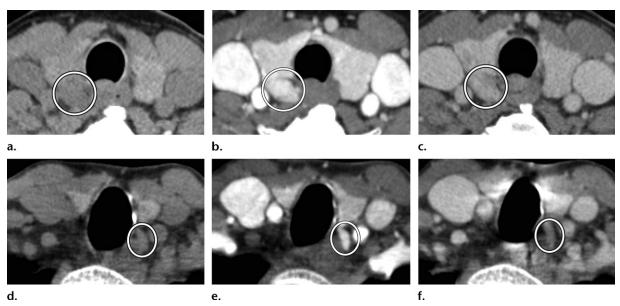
Classic parathyroid adenoma appearance at 4D CT in two patients. Images a-c were obtained in one patient, and images d-f were obtained in a second patient. Axial 4D CT images show that the parathyroid adenomas (circle) are hypoattenuating relative to the thyroid on non-contrast-enhanced images (a, d), are hyperattenuating on the arterial phase images (b, e), and are hypoattenuating (washout) on the venous phase images (c, f). This enhancement pattern is also referred to as type A.
